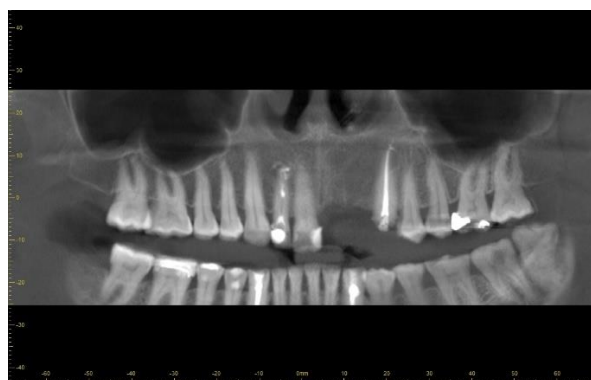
Orthopantomogram (O.P.G).
